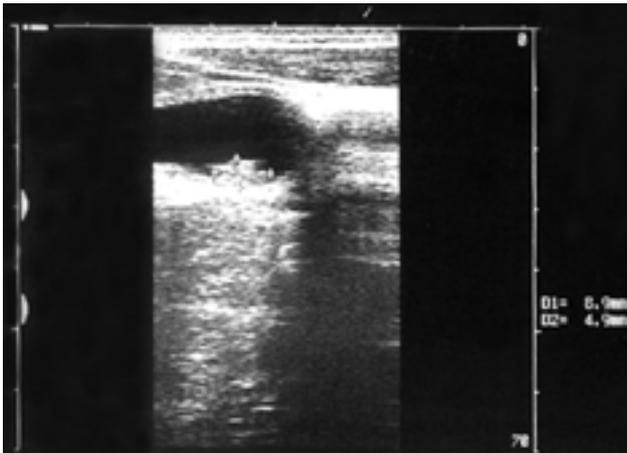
The ultrasonographic appearance of the hypoechoic lobulated contoured lesion in the gall bladder
